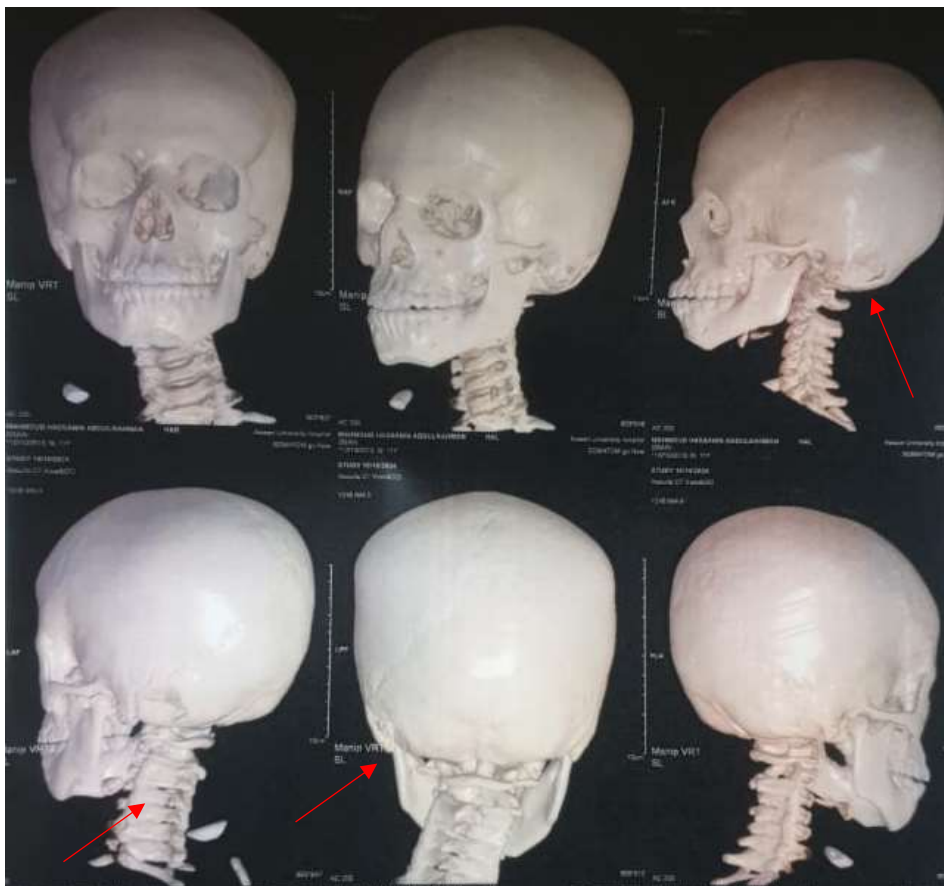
3D reconstruction of CT showing cosmetic disfigurement and external appearance of the fracture. Red arrow showing location of the fracture
